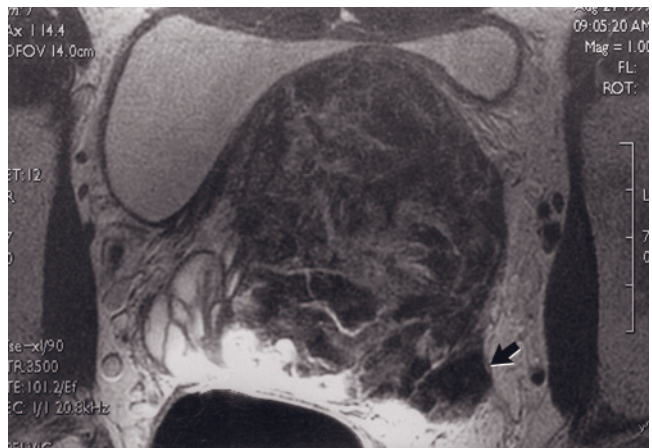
Prostate cancer with hemorrhage in the left seminal vesicle after biopsy. Fat-suppressed T1-weighted gradient-echo (a) and T2-weighted ETSE (b) images. Diffuse increased signal intensity in the left seminal vesicle on T1-weighted images (a) and diffuse low signal on T2-weighted images (b) are consistent with hemorrhage related to biopsy changes.
